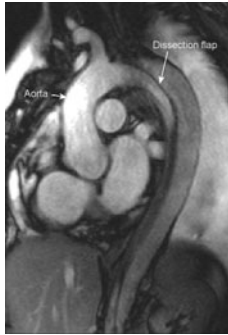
MRI of a type B aortic dissection. There is a dissection flap in the descending aorta
